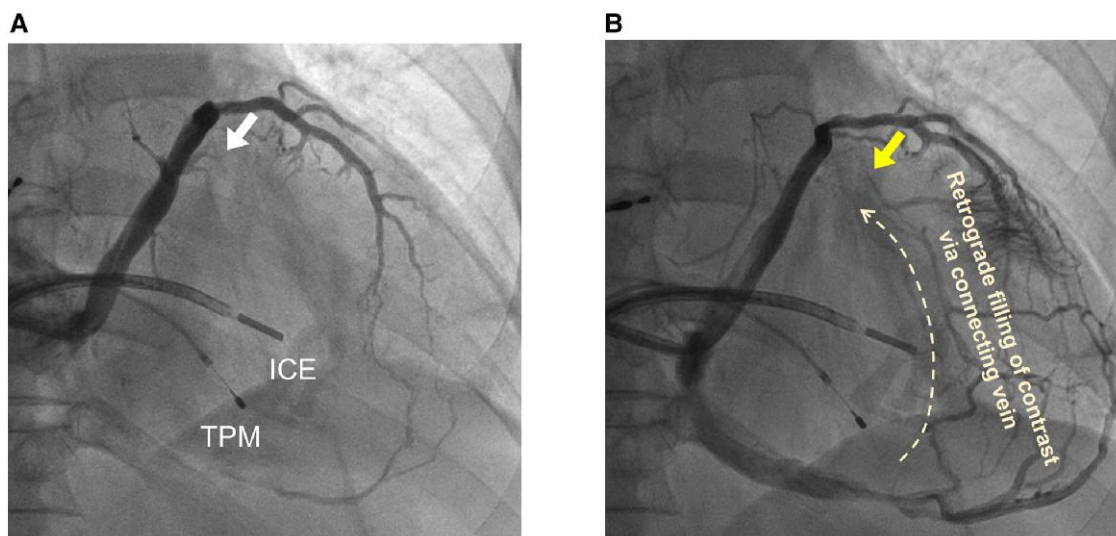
Venography of the cardiac venous system after coronary sinus lead extraction. (A) After coronary sinus lead extraction, the proximal portion of the vessel (arrow) in which the old coronary sinus lead was previously located was not visualized by contrast injection. (B) The distal portion of the target vessel (arrow) was visualized by the retrograde flow (dashed arrow) of contrast via the connecting vessel. CS, coronary sinus; ICE, intracardiac echocardiography, LV, left ventricle; RV, right ventricle; TPM, temporary pacemaker.
